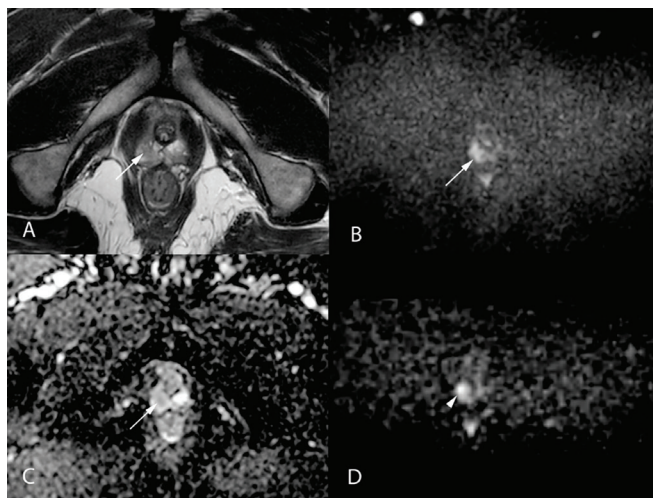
T2W (A), b1400 DWI (B), ADC (C) images of a patient with cancer in the right peripheral zone at the prostate gland apex show tumour tissue (arrows), however, tumour tissue is more prominent in reduced FOV DWI (D) (arrowhead)
